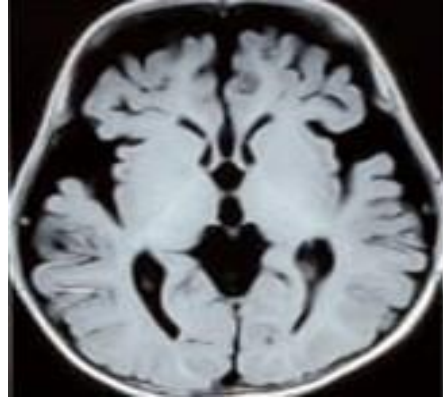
Axial T-1 weighted MRI showing enlargement of subarachnoid spaces in the frontal and temporal regions.
